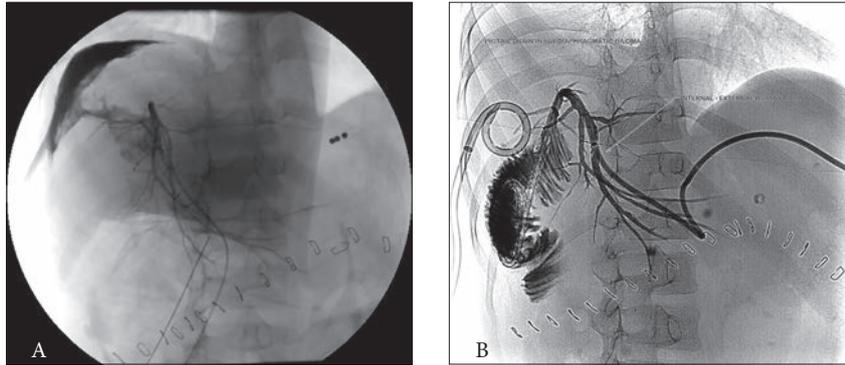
Bile duct leak in a 7-year-old patient with a split liver transplant for Wilson's disease. He presented with raised liver enzymes and right subdiaphragmatic fluid seen on ultrasound. (A) PTC demonstrates non-distended bile ducts and an anastomotic leak at the hepaticoenterostomy, continuous with a right subdiaphragmatic biloma. There is no contrast in the Roux loop, which suggests a complete disruption of the hepaticoenterostomy anastomosis. (B) The patient had surgical revision of the hepaticoenterostomy and at the same time an intraoperative internal-external biliary drain was inserted. A percutaneous pigtail catheter was inserted into the subdiaphragmatic biloma under image guidance. (PTC = percutaneous transhepatic cholangiogram.)
